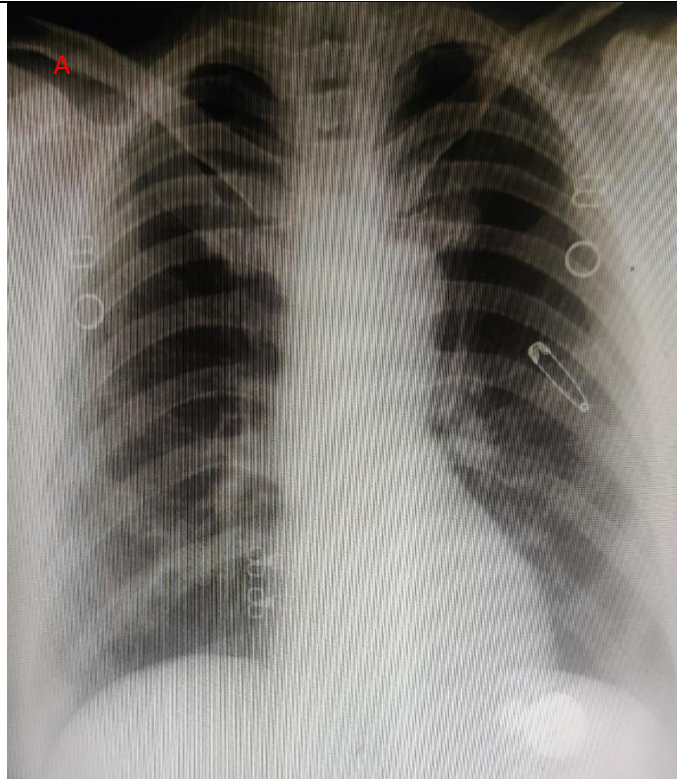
A radiograph of a female. B: Inverted Radiograph.
